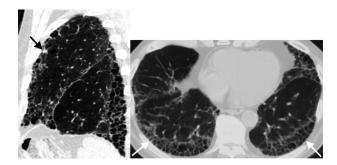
Eighty-two-year-old man with idiopathic pulmonary fibrosis and an indeterminate subpleural solid left upper lobe nodule. Left: Sagittal CT image demonstrates the nodule (arrow) and honeycombing with an apical basilar gradient consistent with a usual interstitial pneumonia pattern. Right: Axial CT image of the lung bases demonstrates stacked cystic structures (arrows) consistent with honeycombing.
